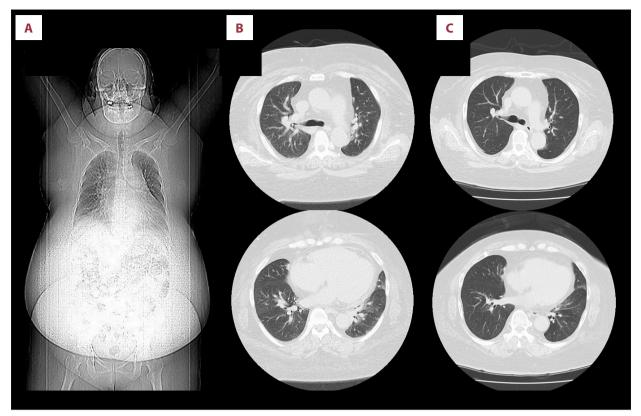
Changes in imaging findings over a 5-year period. (A) A scout image of a chest computed tomography (CT) at first admission demonstrates significant obesity. (B) A chest CT shows bilateral lung congestion without features suggesting other lung diseases and remarkable cardiac enlargement. (C) A CT showing no findings suggestive of heart failure or other abnormality in both lung fields when the patient lost more than 30 kg 5 years following her initial admission.
